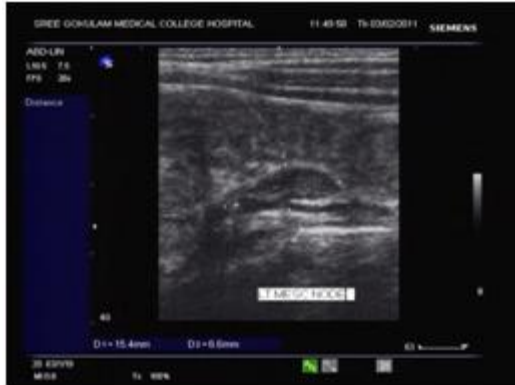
Transverse sonogram of the LLQ showing a node of size 15mm
